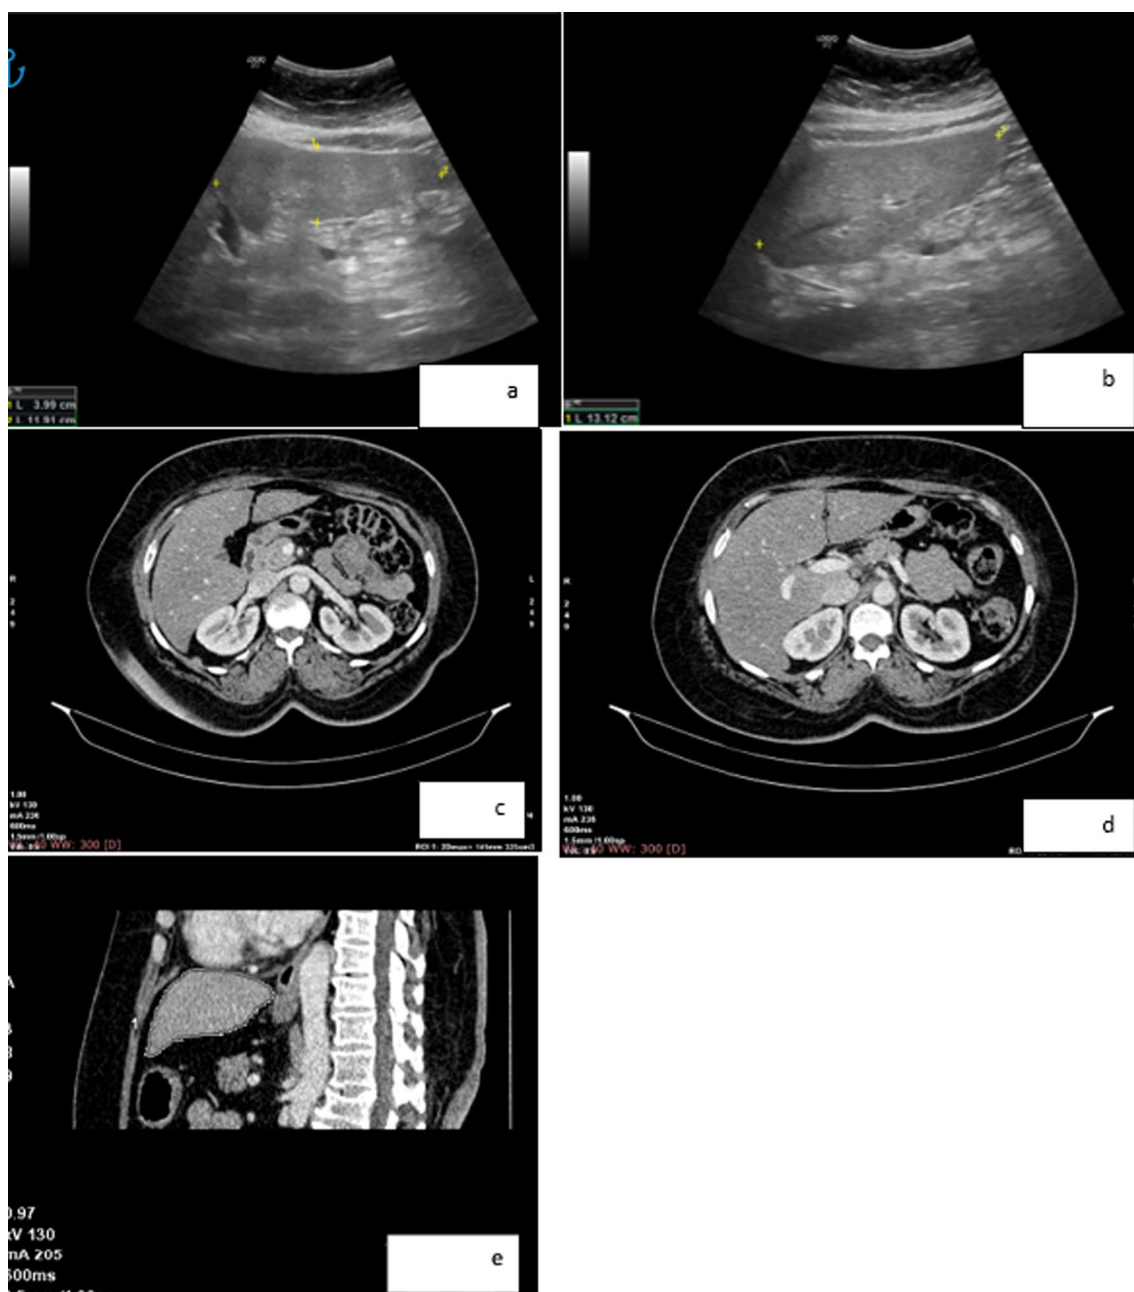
a–e US and CT images for 59 years old female with a BMI = 42. a and b US images measuring the height, length, and width with the estimated LHL volume by ultrasound = 324.3 cm³. c and d axial CECT images and e sagittal CECT image estimating the LHL volume = 325 cm³
